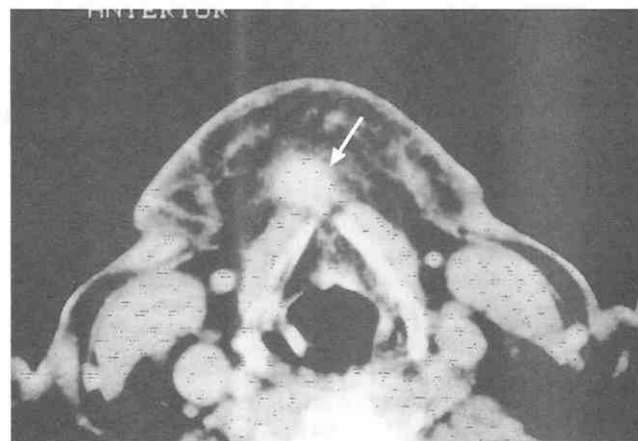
Infected thyroglossal duct cyst. Axial postcontrast CT scan at the level of the upper thyroid cartilage demonstrates an enhancing, slightly heterogeneous soft tissue mass (arrow) within the anterior cervical space. Stranding within the fat surrounding the lesion suggests infection.
